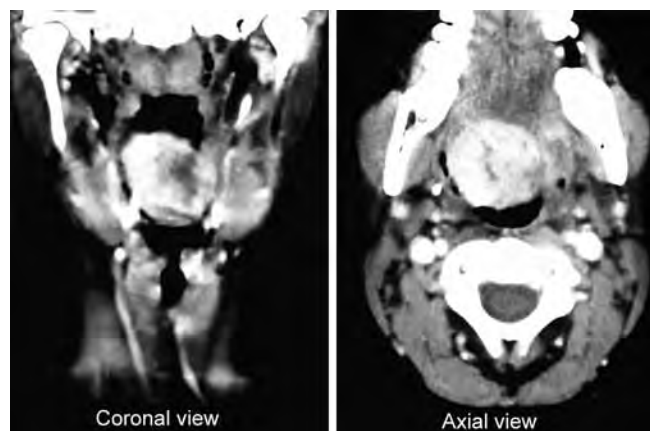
Contrast enhanced computed tomography neck (coronal and axial sections) showing a large heterogeneously enhancing mass in the base of tongue region with nonvisualization of normal thyroid gland in the neck
